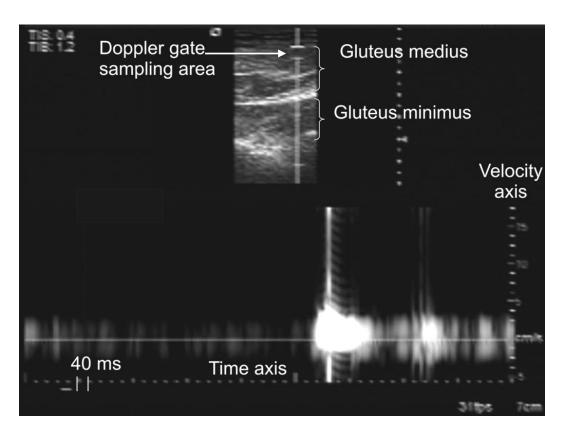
Pulsed Wave Doppler display of activity of the superficial gluteus medius in 60% MVIC.
